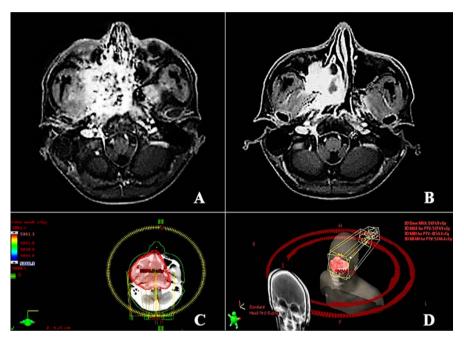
The patient was treated with VMAT. (A) MRI of the head before treatment. (B) MRI of the head follow-up 20 months after the end of radiotherapy. (C) and (D): Treatment with VMAT granted. Abbreviations: MRI: Magnetic Resonance Imaging, VMAT: Volumetric Modulated Arc Therapy.
